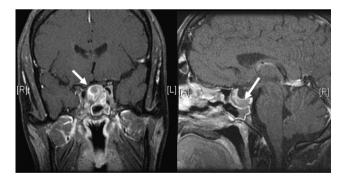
Coronal (left) and sagittal (right) gadolinium enhanced T1 weighted MRI images revealing a pituitary macroadenoma (white arrows). The adenoma extends into the left cavernous sinus surrounding the internal carotid artery and approaches the optic nerves anteriorally.
